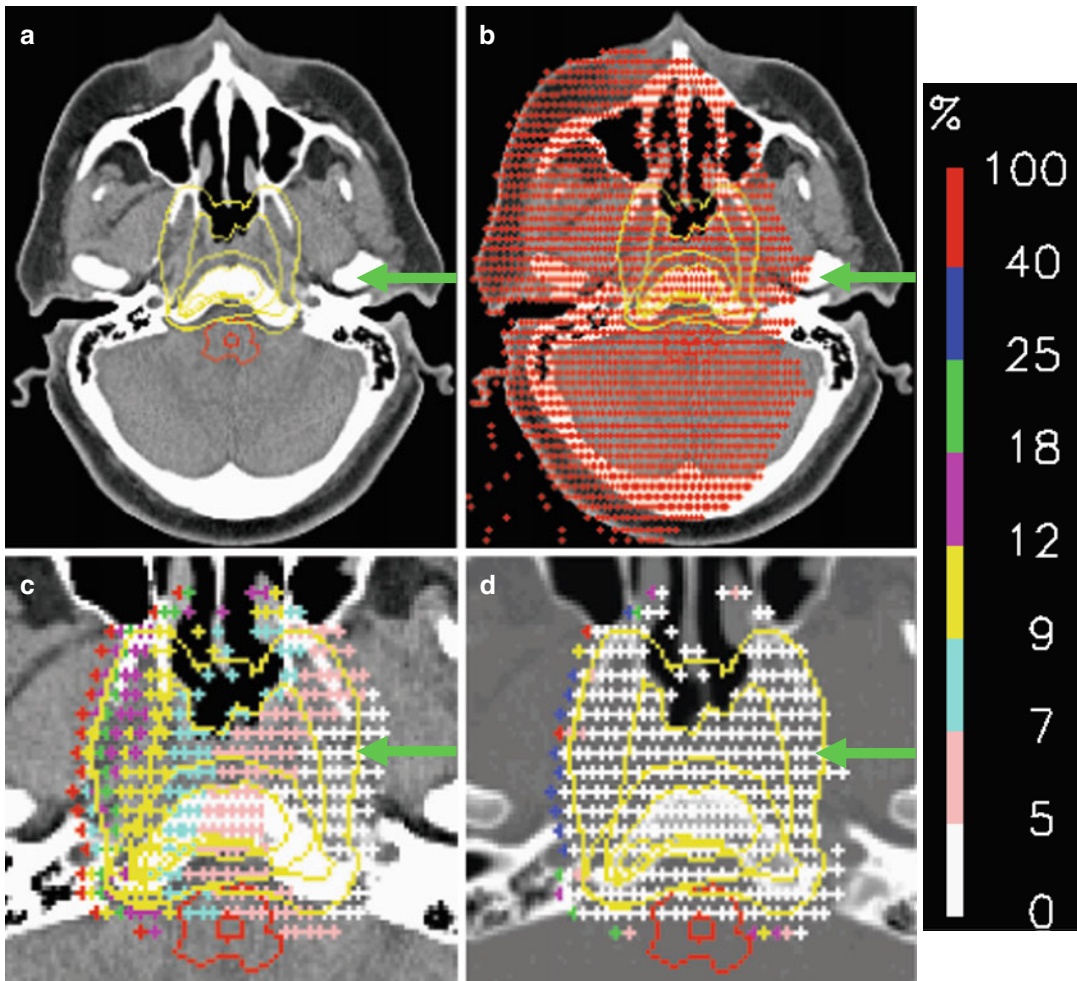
Stages of the planning process for PBS: (a) Planning CT, (b) All deliverable BPs, (c) Selected and pre-weighted BPs, (d) Optimized BPs
